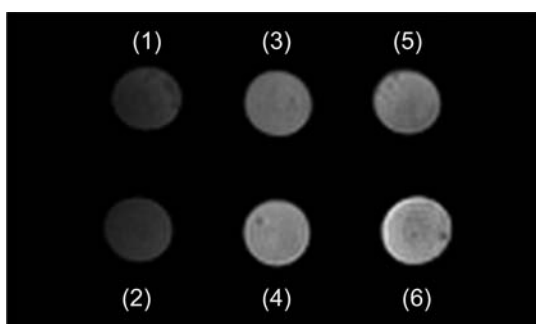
MR images of F-PVA-Gd-labeled MSCs embedded in 2 wt % agarose gel at the cell concentration of (1) 0, (2) 1.0×10^6 , (3) 5.0×10^6 , (4) 7.5×10^6 , (5) 1.0×10^7 , and (6) 2.0×10^7 cells/100 μ L. T_1 -weighted images of the samples were acquired at TE of 9 ms and TR of 1000 ms using a 3D spin echo sequence (FOV, 4 \times 8 cm; matrix, 128 \times 256; slice thickness, 1 mm; slice gap, 0 mm; number of slices, 35).
